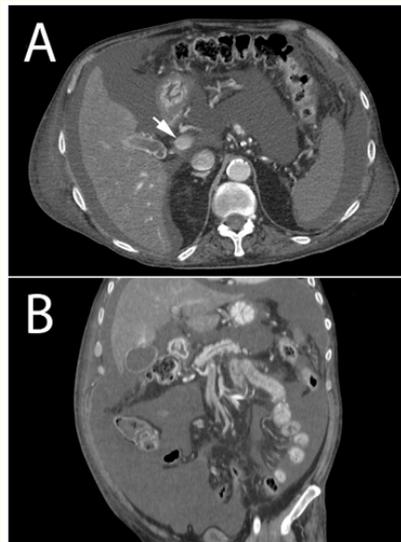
Axial (panel A) and coronal (panel B) contrast-enhanced CT images of the abdomen showing diffuse ascites, but normal liver size and margins (B) and normal spleen size (A). The white arrow depicts patent portal vein in contrast-enhanced portal-venous phase image (A).
